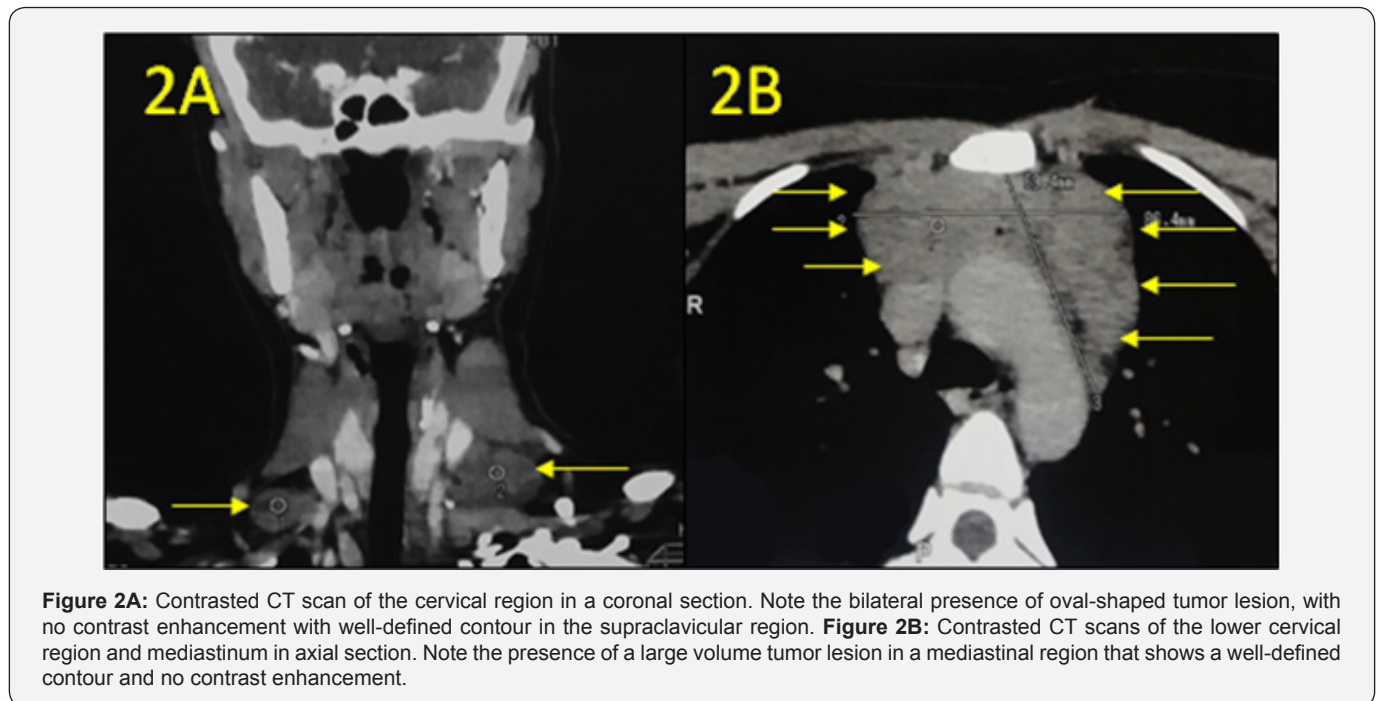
Contrast CT scan of the cervical region in a coronal section. Note the bilateral presence of oval-shaped tumor lesion, with no contrast enhancement with well-defined contour in the supraclavicular region. Figure 2B: Contrast CT scans of the lower cervical region and mediastinum in axial section. Note the presence of a large volume tumor lesion in a mediastinal region that shows a well-defined contour and no contrast enhancement.
